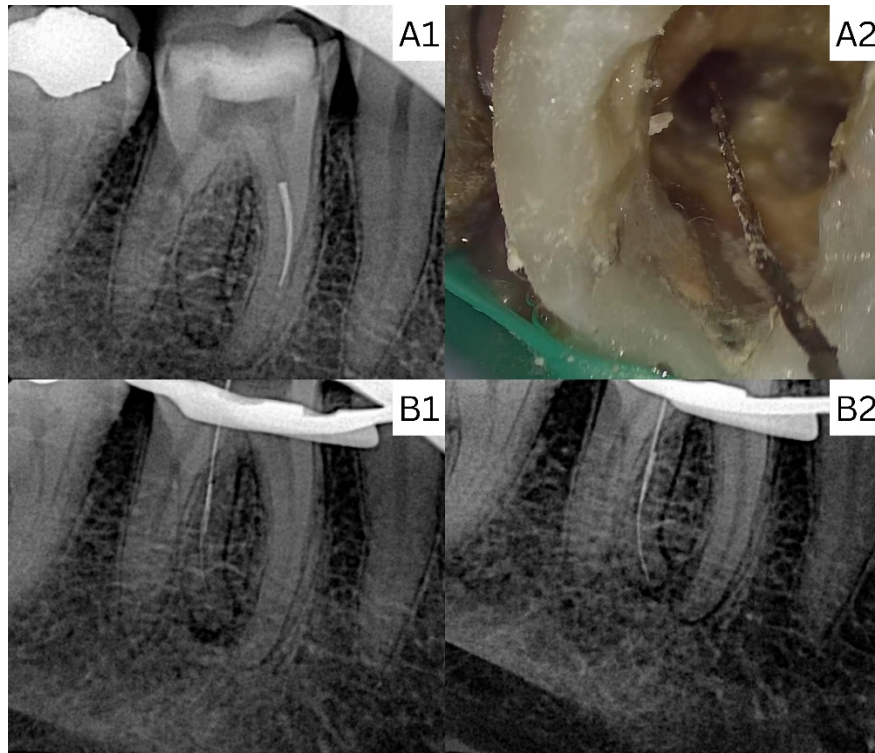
Figure Mandibular right first molar: A1) radiograph of the broken file in the mesiobuccal canal; A2) Photograph from the file retrieval from mesiobuccal canal; B1) Orifice shaper file broken in radix, C file #10; B2) Bypassing the broken file
